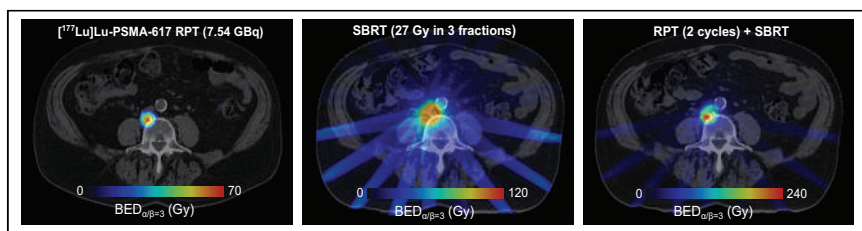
Top: Maximum-intensity projections for 3 [<sup>177</sup>Lu]Lu-PSMA-617 SPECT/CT scans of patient 4. Oligorecurrent lymph nodes in lower retrocaval (blue arrow), right posterior common iliac (red arrow), and superior presacral (orange arrow) regions. Bottom: Axial CT slices, centered on lower retrocaval lymph node.
